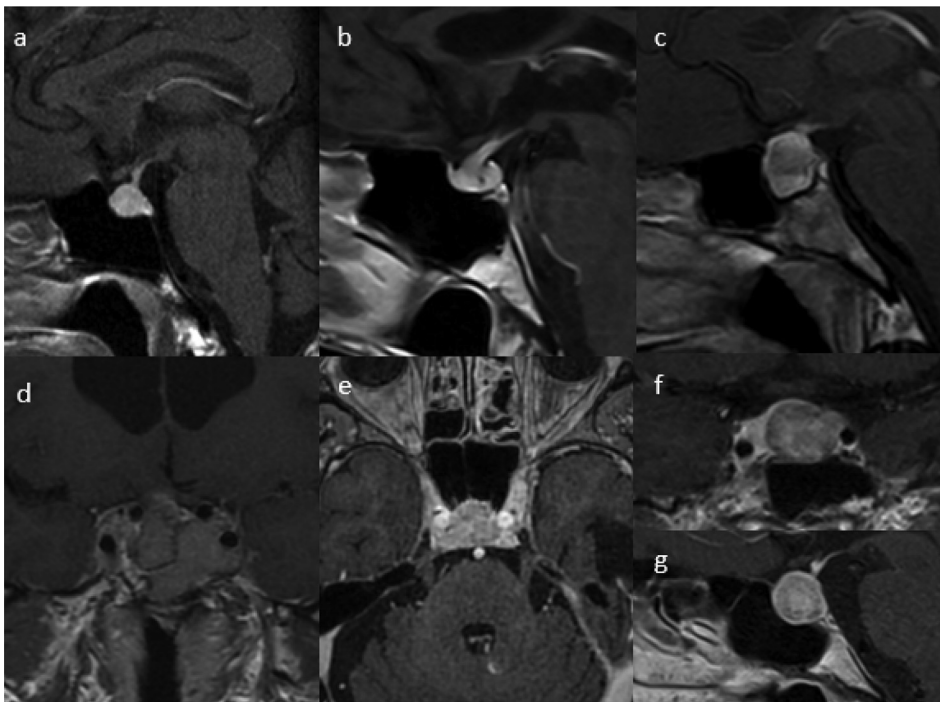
Prospective evaluation of the image-driven algorithm. ICB-induced hypophysitis (a–c) versus pituitary metastases (d–g) on oncological follow-up imaging (post-contrast T1-weighted MRI: sagittal (a, b, c and g), coronal (d and f), and axial (e)). All lesions were correctly predicted as HP or PM by our image-driven algorithm. (a): Enlarged homogeneously enhancing pituitary gland with a mildly thickened stalk. (b): Marked thickening of the pituitary stalk. (c): Enlarged pituitary (<2 cm, no cavernous extension) with heterogenous enhancement. (d): Enlarged (≥ 2 cm, with cavernous extension), heterogeneously enhancing pituitary gland in a patient treated for NSCLC. (e and f–g): Enlarged (<2 cm, with cavernous extension), heterogeneously enhancing pituitary glands in 2 patients treated for RCC. HP = hypophysitis; PM = pituitary metastasis; RCC = renal cell carcinoma; NSCLC = non-small cell lung cancer; MRI = magnetic resonance imaging.
